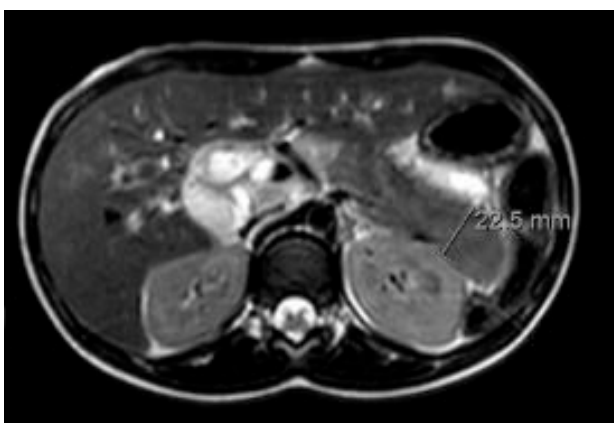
Magnetic resonance imaging of the abdomen, showing the enlarged pancreas with a typical "sausage-like" aspect
